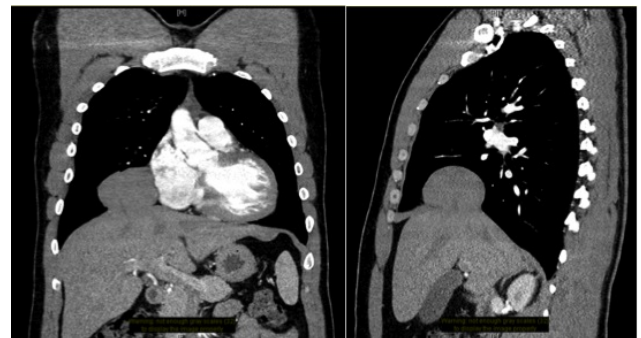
Coronal and midsagittal CT scan showing herniated liver segment.
